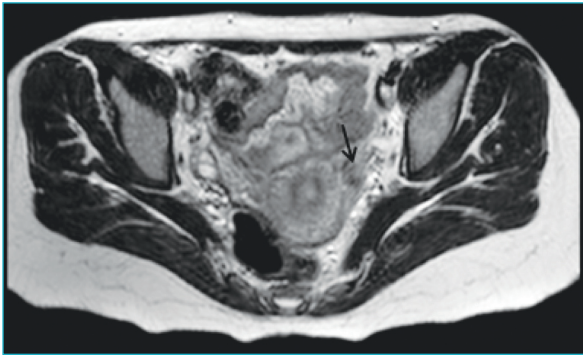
T2 weighed axial magnetic resonance imaging view of a patient with a missing copper intrauterine device (showed by arrow).
